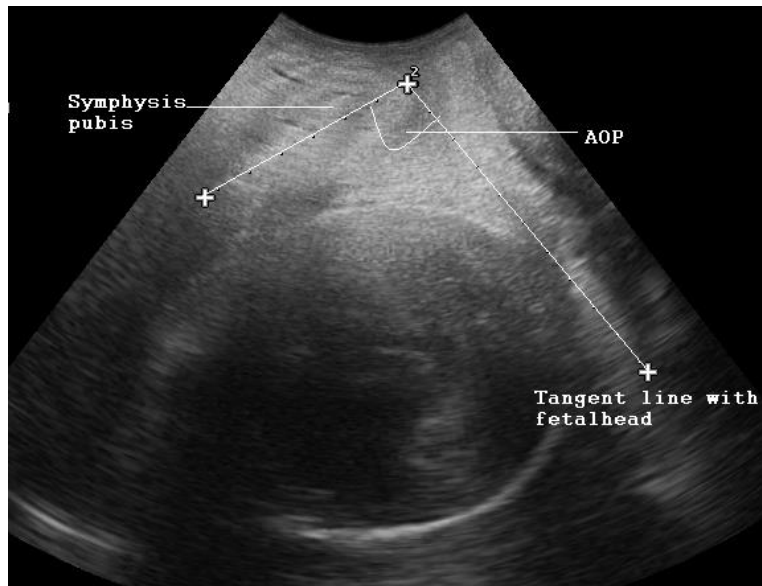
An example of AoP sonographic image (Source: Wiafe et al (2016))
